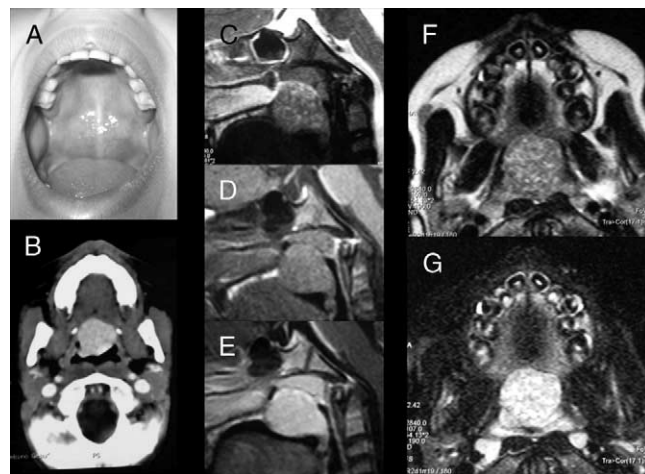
Preoperative findings. A, An intraoral mass deforming posterior soft palate without mucosal ulcerations. B, Contrast-enhanced CT scan showed a solid lesion associated to homogeneous and intense contrast enhancement. D, On MRI examination, the pathological tissue was characterized by mild hyperintense signal on T1-weighted images compared to tongue signal. An inhomogeneous hyperintensity on T2-weighted, “salt and pepper” like (C, F), and homogeneous enhancement after contrast injection was evident (E, G). The mass lesion appeared well distinguishable with respect to the surrounding anatomical structures.
